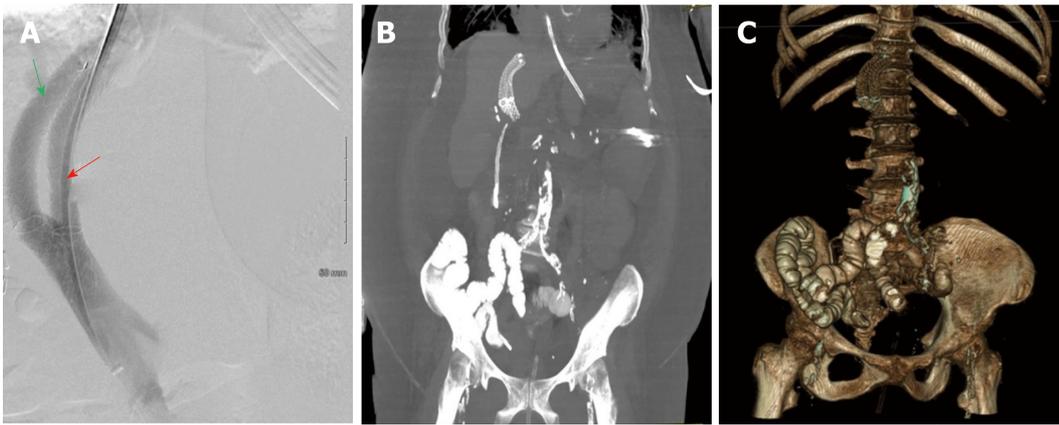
Treatment for patient 3. A: Digital subtracted portal angiography showing successful placement of the parallel stent (red arrow). Primary stent (green arrow) is perfectly parallel along the second transjugular intrahepatic portosystemic shunts stent. B: Maximum intensity projection with 30-mm slab of a post procedural computed tomography (CT) abdomen showing primary and parallel stents in tandem. C: 3D reconstruction of post procedural CT abdomen showing primary and parallel stents in tandem.
